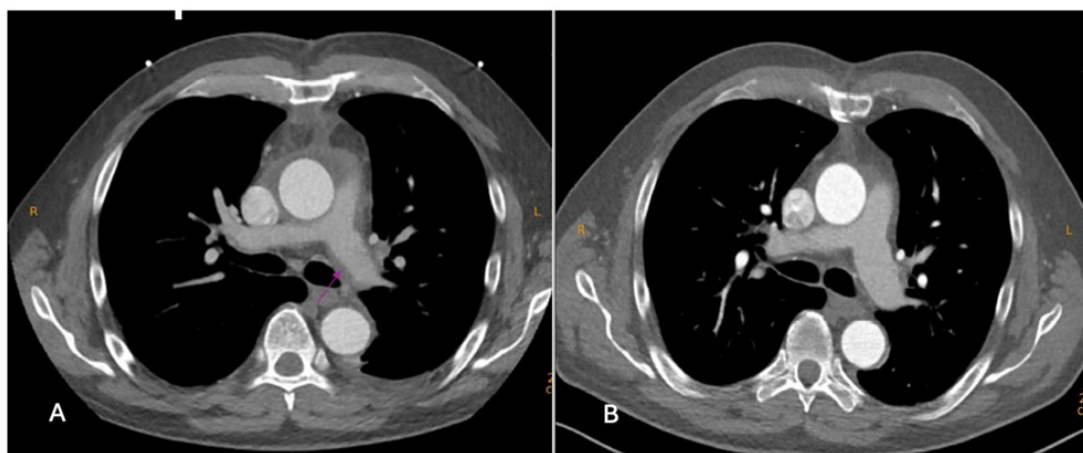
A) Cardiac computer tomography angiography - Triple rule out protocol showing preoperative diameter of the right ventricle of 62mm. B) CT angiography of the aorta on the 13th postoperative day: showing reduced diameter of the right ventricle to 47 mm (Rhön-Klinikum Campus Bad Neustadt, Germany, 2024)
